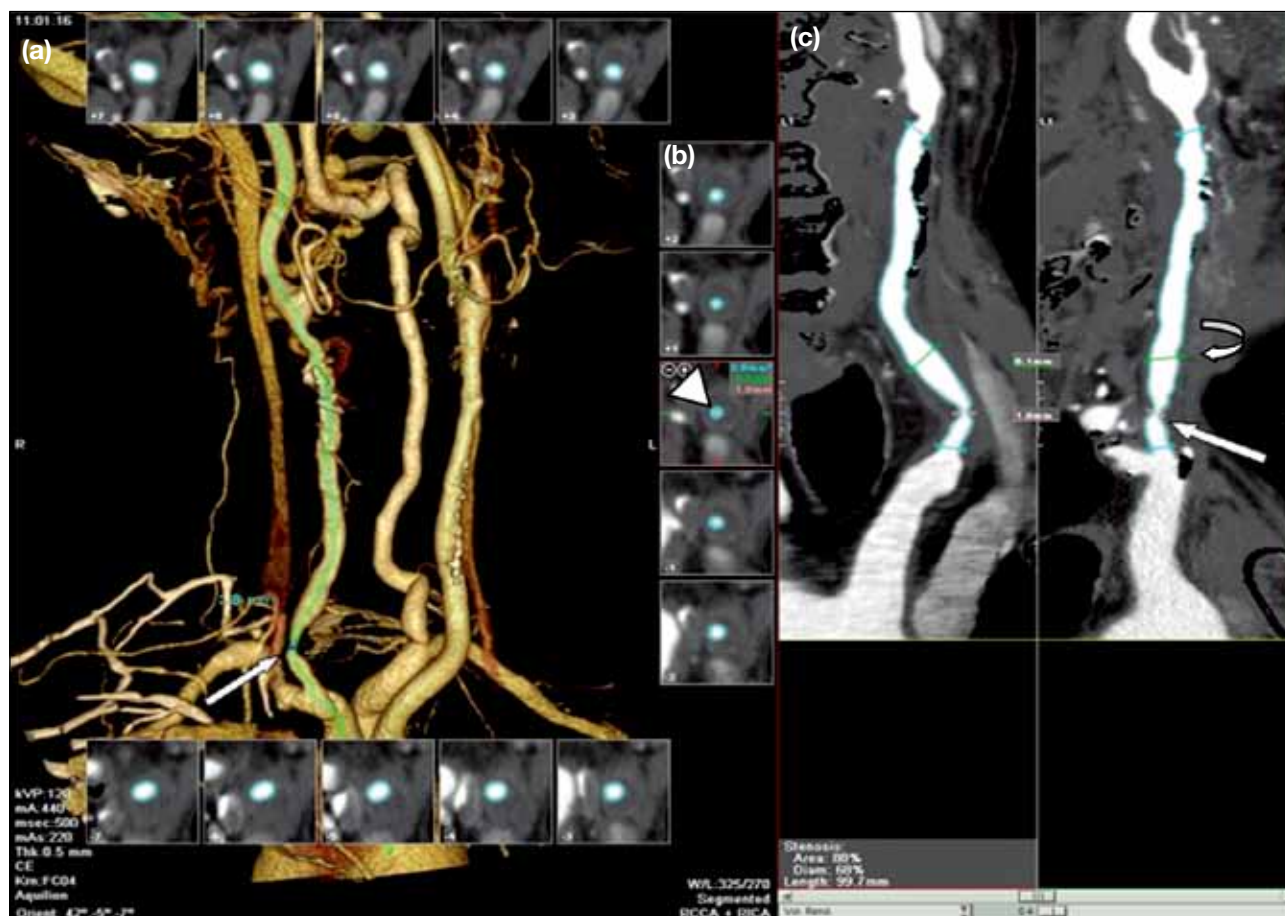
Stenosis of right common carotid artery (CCA) in a 75-year-old man with cerebrovascular accident who presented with left hemiparesis. The patient had a history of nasopharyngeal carcinoma treated with radiotherapy more than 20 years ago. He also had a history of smoking, hypertension, diabetes mellitus, and hyperlipidaemia. The reformed images were generated from multidetector row computed tomography data for vascular analysis. (a) A 3-dimensional volume-rendering image provides an overview of the stenotic lumen (arrow) in the proximal third of the CCA. (b) Cross-sectional multiplanar reformation images at different levels demonstrate varying degrees of luminal enhancement. The narrowest level (arrowhead) had a diameter of 1.9 mm and was defined as the lesion site (L). (c) Curve planar reformation images show the corresponding lesion site (arrow). The normal-looking level of the CCA (curved arrow) distal to the lesion site had a diameter of 6.1 mm and was defined as the reference site (R). The calculated degree of diameter stenosis by the NASCET criteria was 68%. It was defined as significant stenosis by our criteria as the luminal diameter reduction was $\geq 50\%$.
